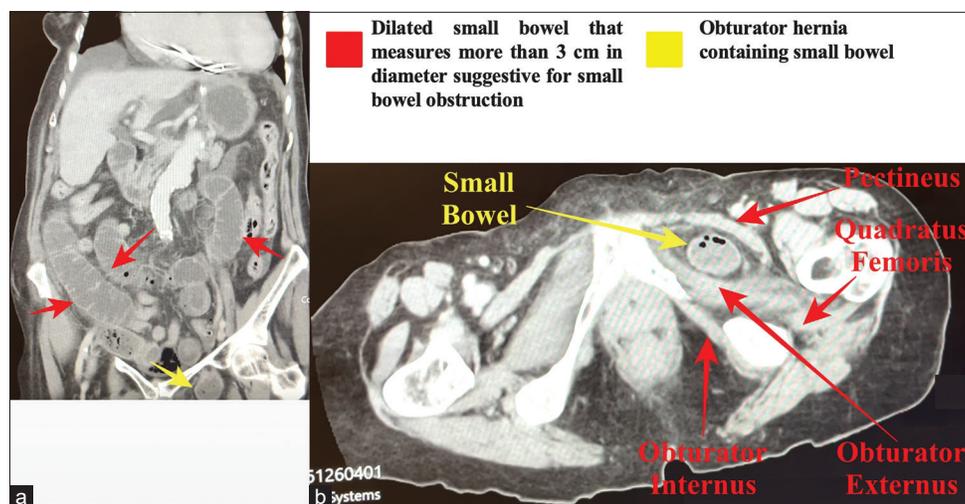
74-year-old female patient who presented with symptoms suggesting bowel obstruction secondary to a strangulated left-sided Obturator hernia (OH). (a) A sagittal slice of contrast-enhanced computed tomography image shows small bowel dilation (red arrows) with caliber change in the left lower quadrant (yellow arrow) (b) Axial image is suggestive of mechanical small bowel obstruction due to an intestine segment strangulated through the obturator left foramen (yellow arrow) trapped between the pectineus and obturator externus muscles (red arrows).
